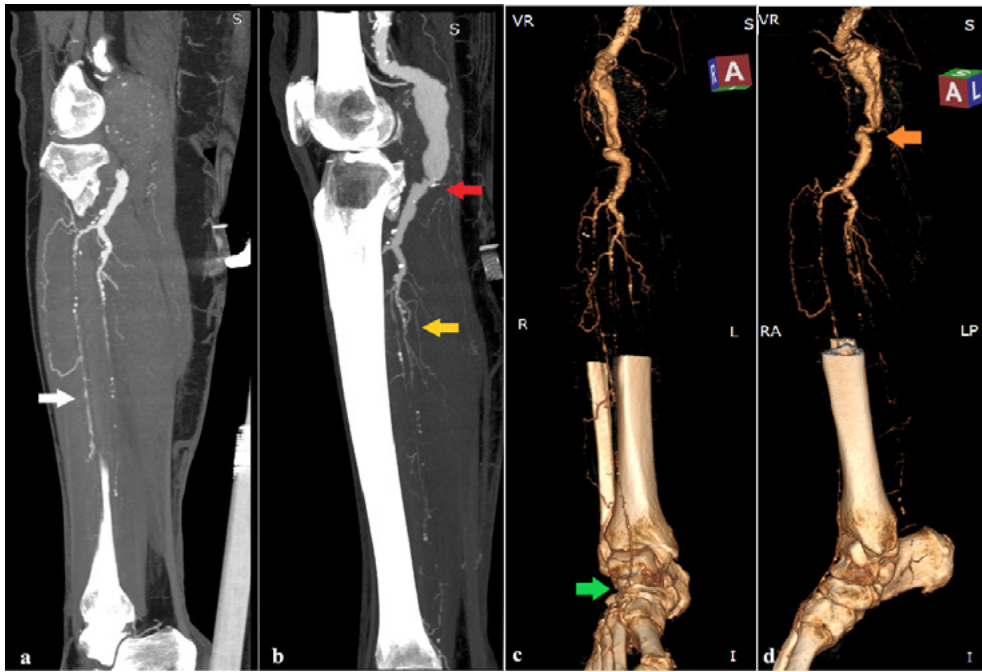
Preoperative Computed Tomography Angiography (CTA) of the Right Lower Limb (RLL). a) On a sagittal plane, white arrow shows the progressively occluded Anterior Tibial Artery (ATA) with beaded appearance and multifocal calcified plaques b) On a sagittal plane, red arrow shows the irregular popliteal lumen due to extensive mural thrombus of the aneurysm. Yellow arrow shows the posterior tibial and peroneal artery with appearance similar to ipsilateral ATA. c) Three-dimensional reconstruction where the green arrow shows the distal thready reconstitution of ATA through the collateral network d) Three-dimensional reconstruction where the orange arrow shows the severe angulation of the distal popliteal artery due to aneurysm formation.
